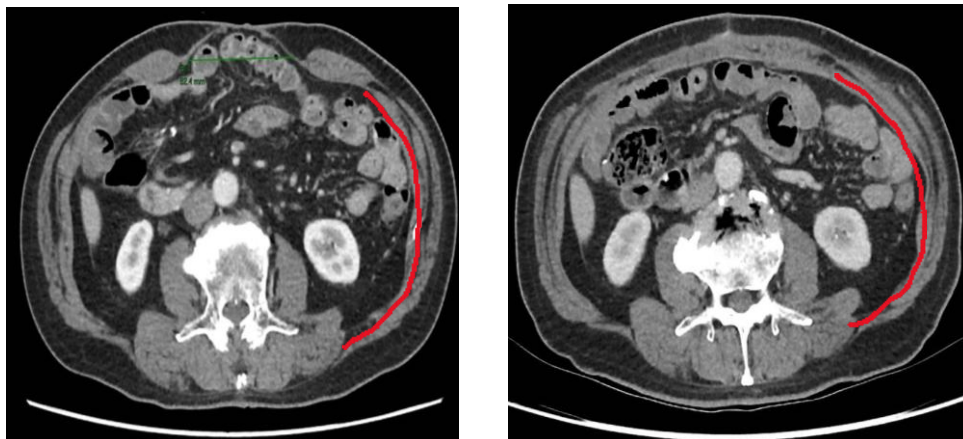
Pre-operative and post operative CT comparisons showing persistent lengthening of LAW musculature and successful primary fascial closure after CS.
